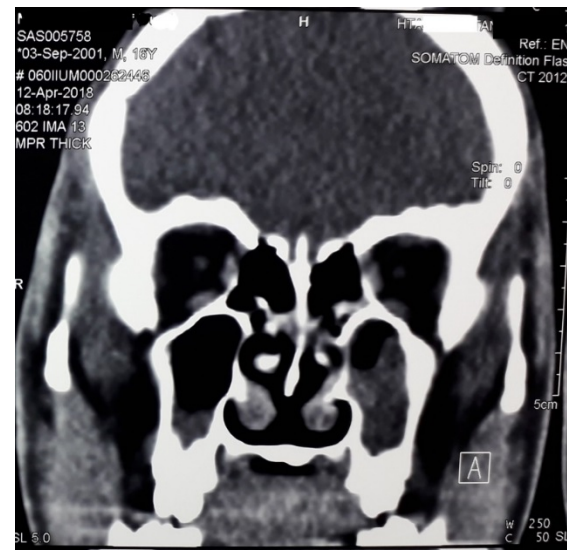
Coronal view of the CT scan (posterior cut) shows absence of vomer.
